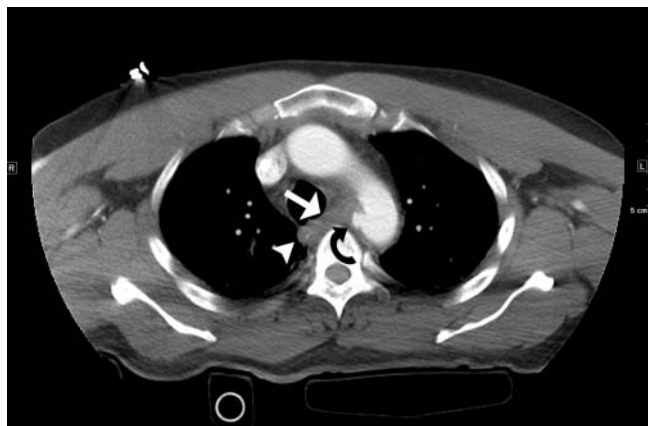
A 40-year-old male who presented to the emergency department following a high-velocity motor vehicle accident with crushing central chest pain. An axial multidetector computed tomographic angiogram at the level of the aortic arch demonstrates increased attenuation material (*white arrow*) within the mediastinum displacing the esophagus (*arrowhead*) to the right. On the medial aspect of the undersurface of the aortic arch, at the level of the relatively fixed aortic isthmus, there is a disruption in the smooth contour of the aortic wall (*curved black arrow*), with a small area of outpouching of contrast. The finding of mediastinal hematoma (*white arrow*), along with aortic disruption in the setting of a motor vehicle accident, is consistent with acute aortic injury known as aortic transection. This requires emergent repair, with many centers now favoring endovascular and/or hybrid methods. This patient underwent a left subclavian arterial transposition. The transposition was performed before covering the transection with a stent graft to preserve the dominant left vertebral artery.
